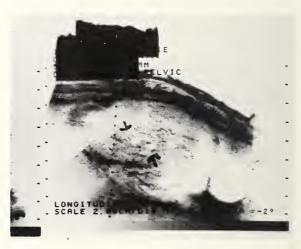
Ultrasound study. Arrows point to systic areas corresponding to hydropic villi.
